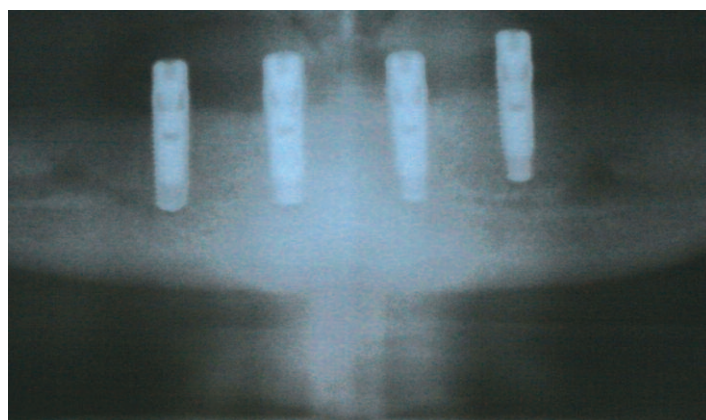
A final radiograph shows implant placement and apparent osseointegration.
